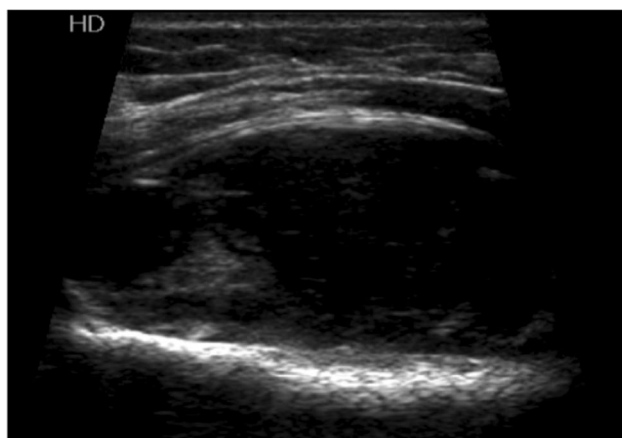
Hypoechoic, heterogeneous oval-shaped mass, with partially defined limits, with no significant blood flow in Doppler analysis, in the middle of the supinator muscle fibers, close to the cortical bone of the radius and close to the radial nerve
